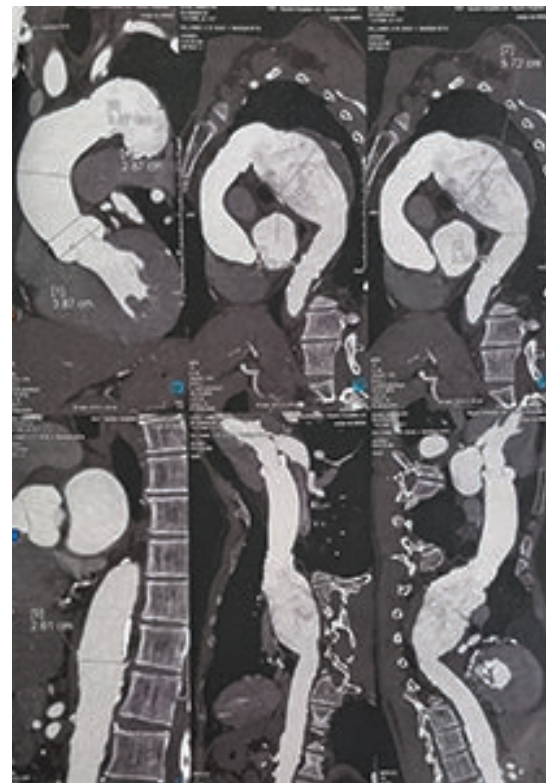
Pre-operative CT scan showing aneurysmal segment of aorta with extent and measurements
